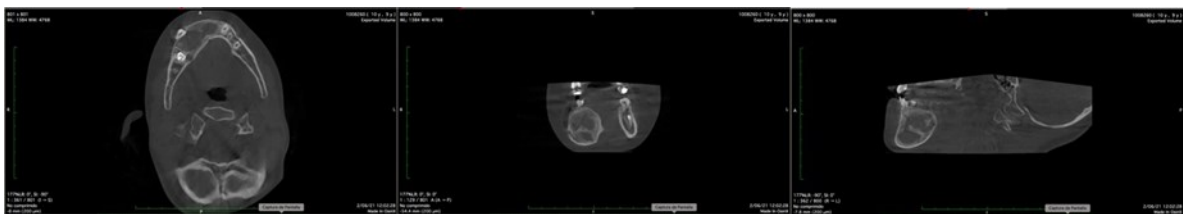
Eleven months CBCT. Concentric bone formation observed from the margin of the lesion to the center.
